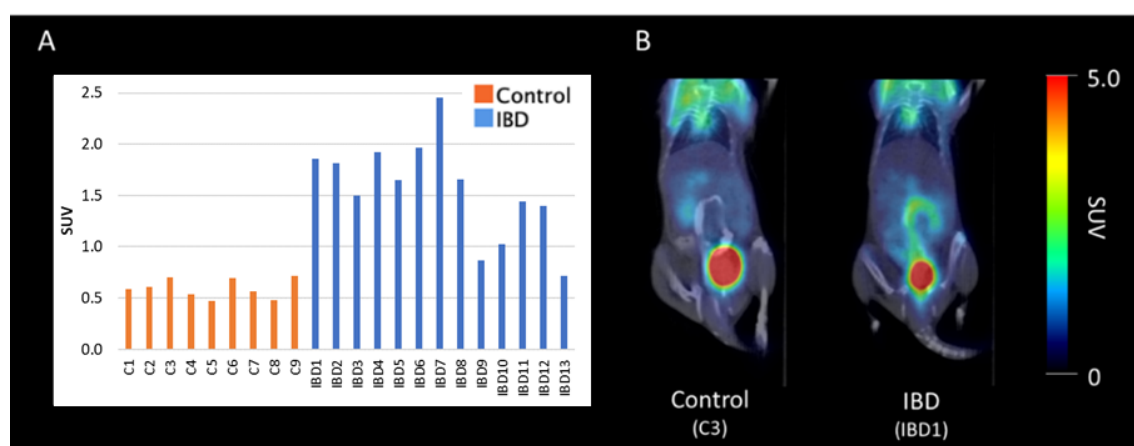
(A) [¹⁸F]FDG SUV values in colon area (B) two examples of [¹⁸F]FDG PET/CT studies expressed as SUV, control (C3) and IBD (IBD1).
